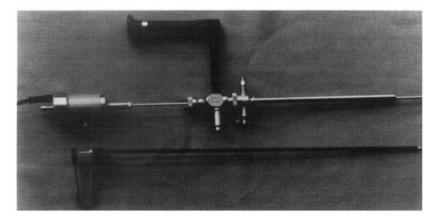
Rigid 24 Fr nephroscope (STORZ) with ultrasonic lithotriptor inserted through its lumen. Grasping forceps are pictured alongside.
